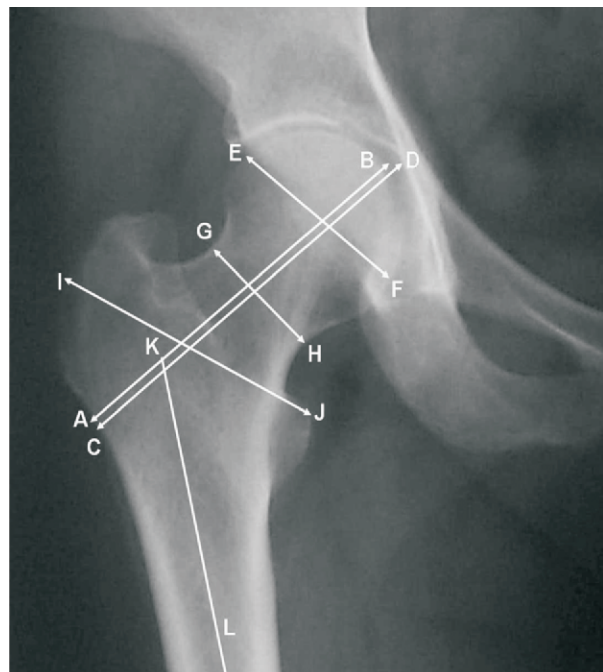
Definition of measured parameters from anteroposterior radiograph of the proximal portion of the femur.
